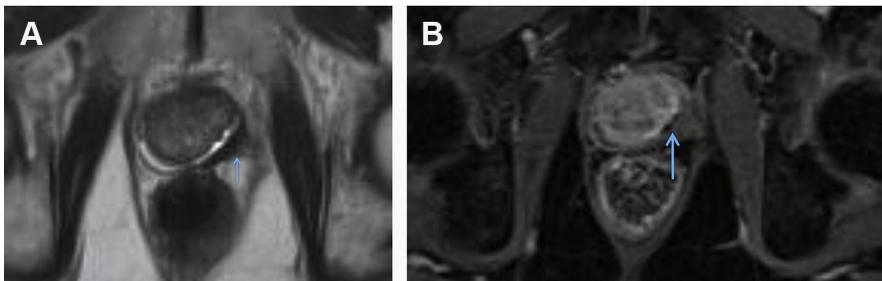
Cryotherapy. Post-cryotherapy MR imaging of a 72-year-old man with a history of a left midgland peripheral zone prostate adenocarcinoma demonstrates asymmetric focal volume loss at the site of treatment. (A) T2-weighted imaging shows ill-defined or amorphous dark signal in the area of treatment in the left midgland. (B) Postcontrast imaging of the prostate gland in the axial plane at the midgland level demonstrates thin linear hypointense signal (arrow) at the treatment site without evidence of focal nodular enhancement.
